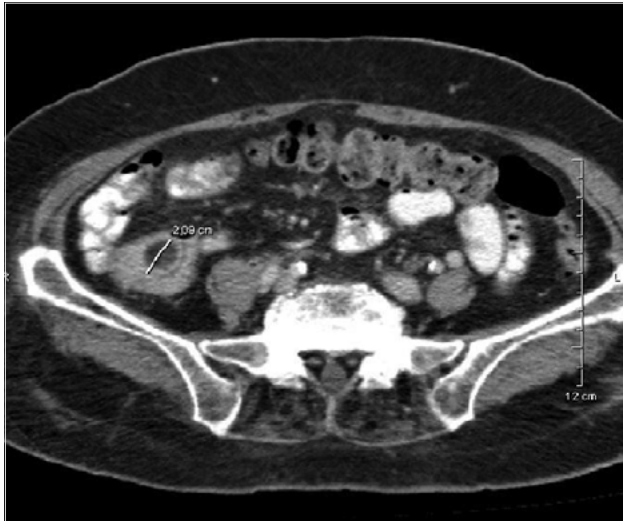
Abdominal CT scan in an axial view showing the submucosal polypoid lesion of the terminal ileum
